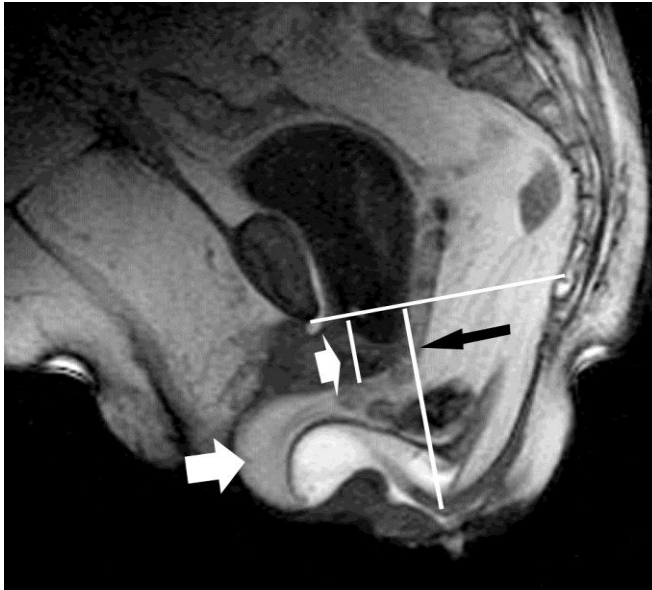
Dynamic MRI. (a) Mid-sagittal steady state free precession T2-weighted image obtained at straining shows landmarks used in the HMO-system. The landmarks are the inferior aspect of the symphysis pubis (*A*) and the posterior wall of the rectum at the level of the anorectal junction (*B*). The H line (*H*) represents the anteroposterior hiatal width and extends from *A* to *B*. The M line (*M*) represents hiatal descent and extends perpendicularly from the pubococcygeal line (*PCL*) to the posterior end of the H line. (b) During Valsalva maneuver, there is a bladder descent below the *PCL* (small white arrow), with a perineal descent (black arrow) and a rectocele developing with a posterior vaginal wall prolapse (long white arrow)
